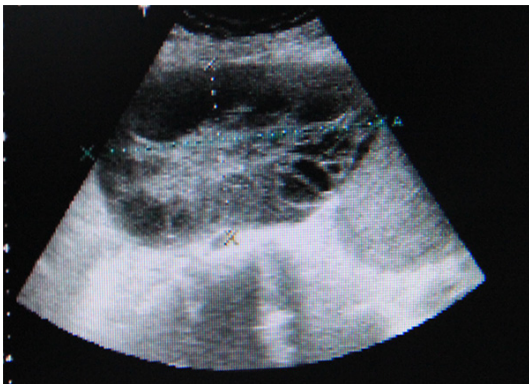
Right ovary in the ultrasoundgram on 7th May, 2014.
